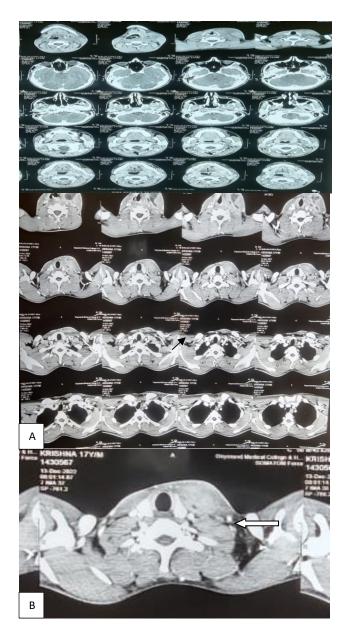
(A and B): CT axial view-Collection in the left para-carotid space. CT axial view-Collection in the left para-carotid space (White arrow).
